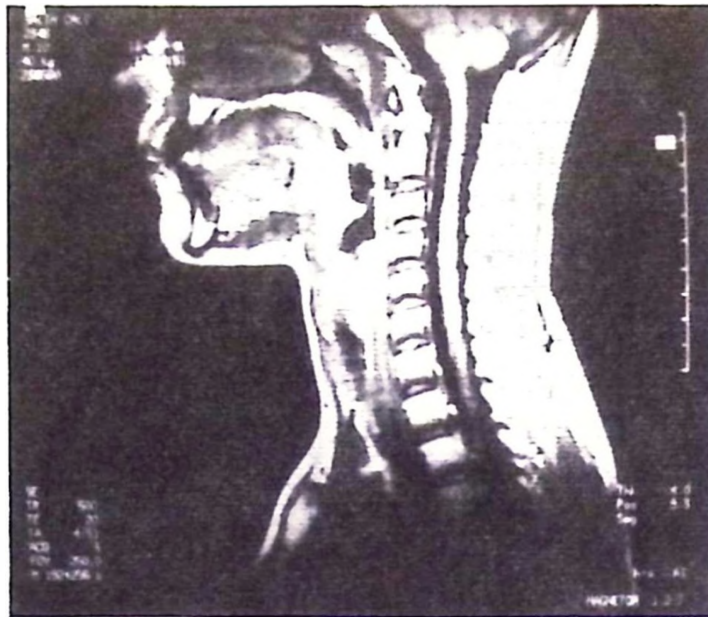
MRI of a 13-year-old patient with a 12-month history of JRA. Odontoid process surrounded by pannus.
